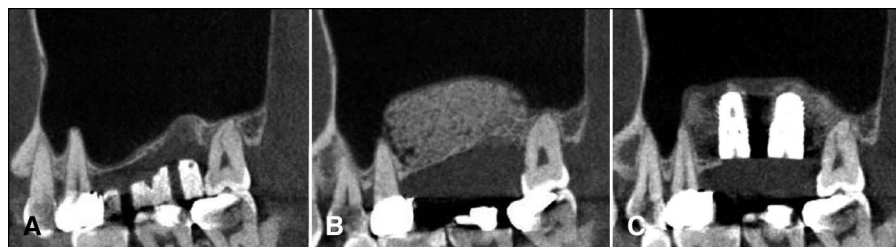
The treatment protocol of the present study for the staged approach. A, The preoperative cone-beam computed tomography (CBCT) radiograph. B, The postoperative CBCT radiograph after maxillary sinus floor augmentation. C, The insertion of the implant 6 months after maxillary sinus floor augmentation.
